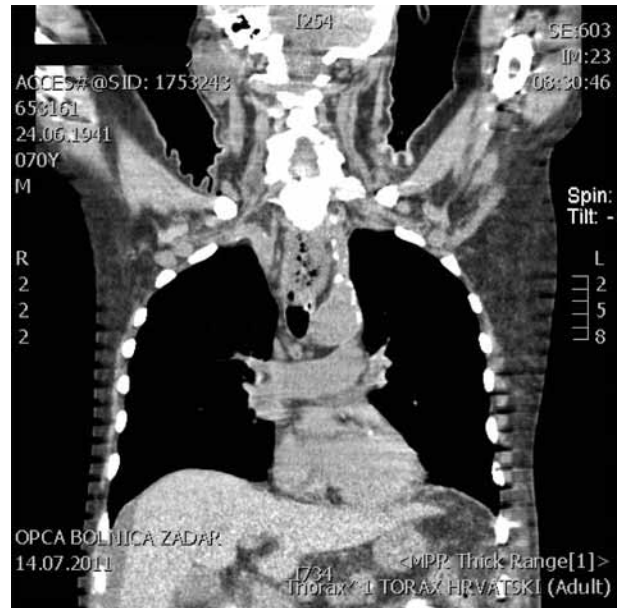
Computed tomography (CT) on hospital day 4 revealed thickening of the posterior upper mediastinum tissues, between the esophagus and vertebral bodies, with a collection of air (A, transverse view; B, frontal view).
